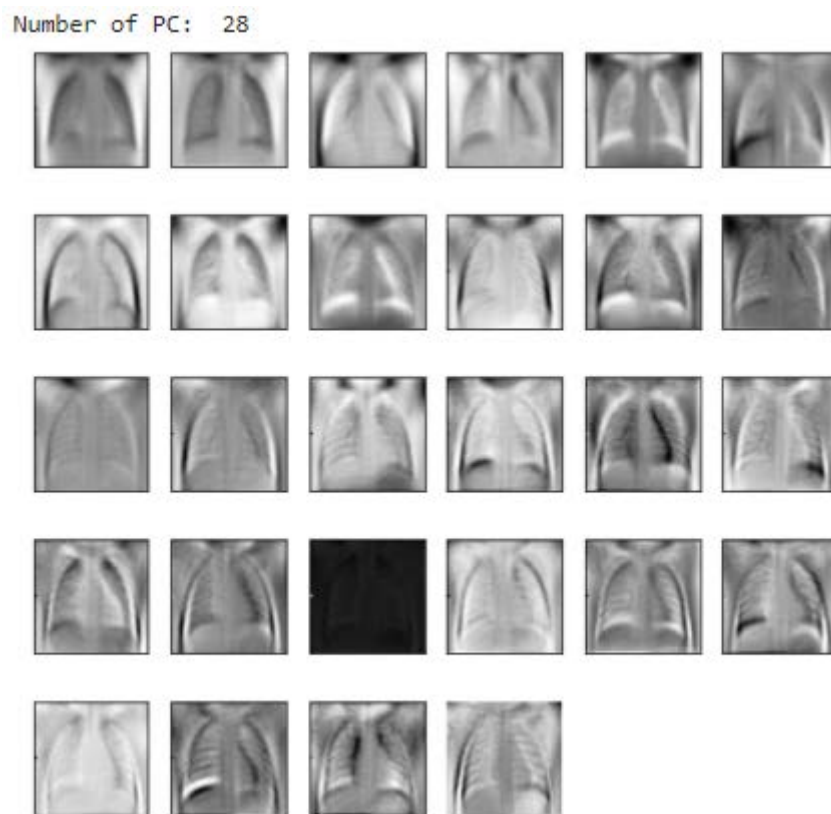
Eigen images of normal X-ray images.
